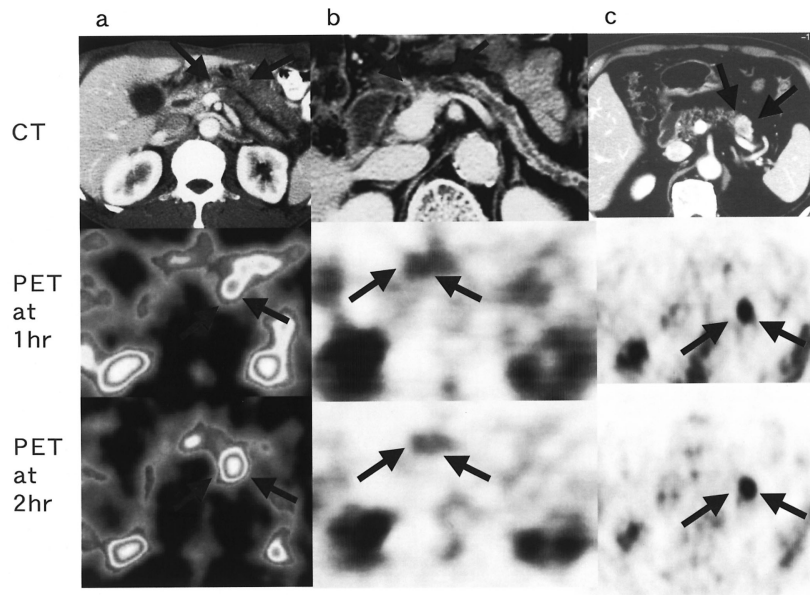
Various uptake patterns observed in delayed FDG PET scan. Figure a shows a pancreatic cancer case that was unclear at the 1 hr scan, but became clear at the delayed scan (2 hours after FDG injection). Figure b shows a pancreatic cancer case that was relatively clear in the 1 hr scan, but became faint and unclear in the delayed scan. Figure c shows a pancreatic cancer case with the lowest retention index value (−25%) in our institute. The contrast-enhanced CT scan (arterial phase) clearly reveals that this tumor is a hypervascular-type pancreatic cancer. This is the only hypervascular-type case in the PET study in our institution, and is relatively unusual for invasive ductal adenocarcinoma. In this case, FDG PET images show decreased FDG uptake in 2 hr scan, which suggested the possible role of vascularity in the wash-out of FDG in the delayed phase.
